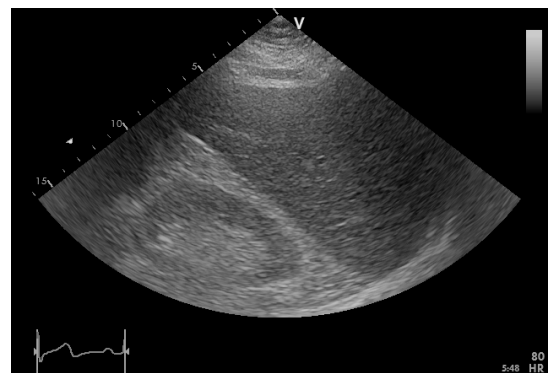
Raw Ultrasound Image [5]
